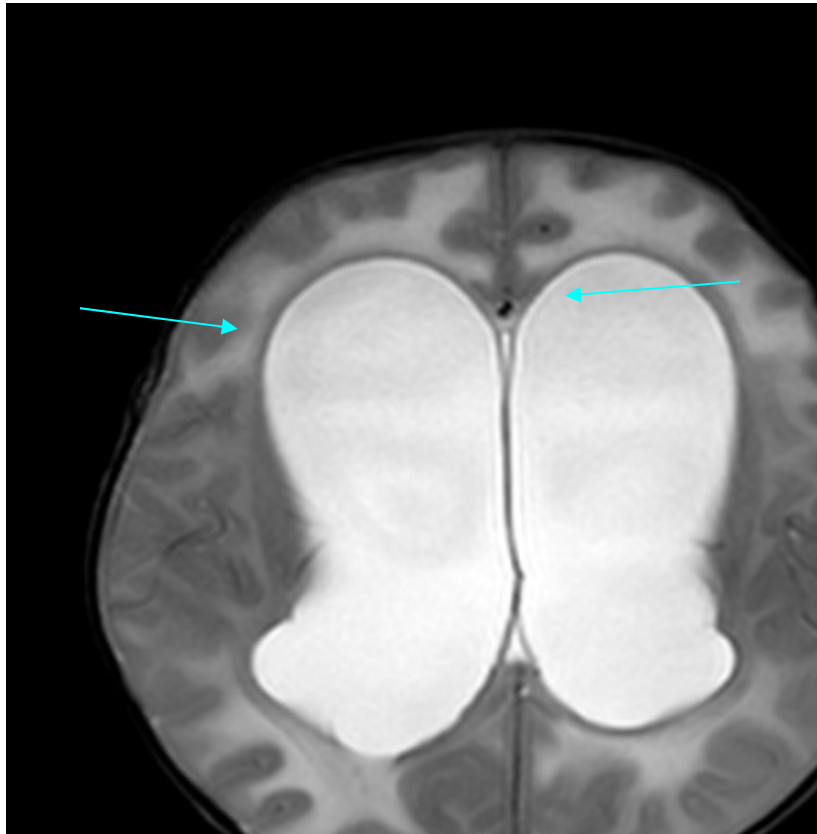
MRI brain contrast enhanced T2 weighted axial view showing gross dilatation of bilateral lateral ventricles
